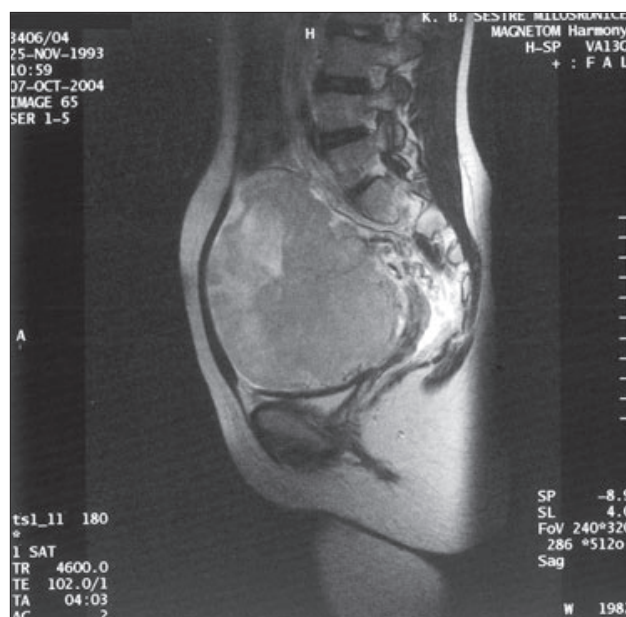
CT scan before surgical treatment.
